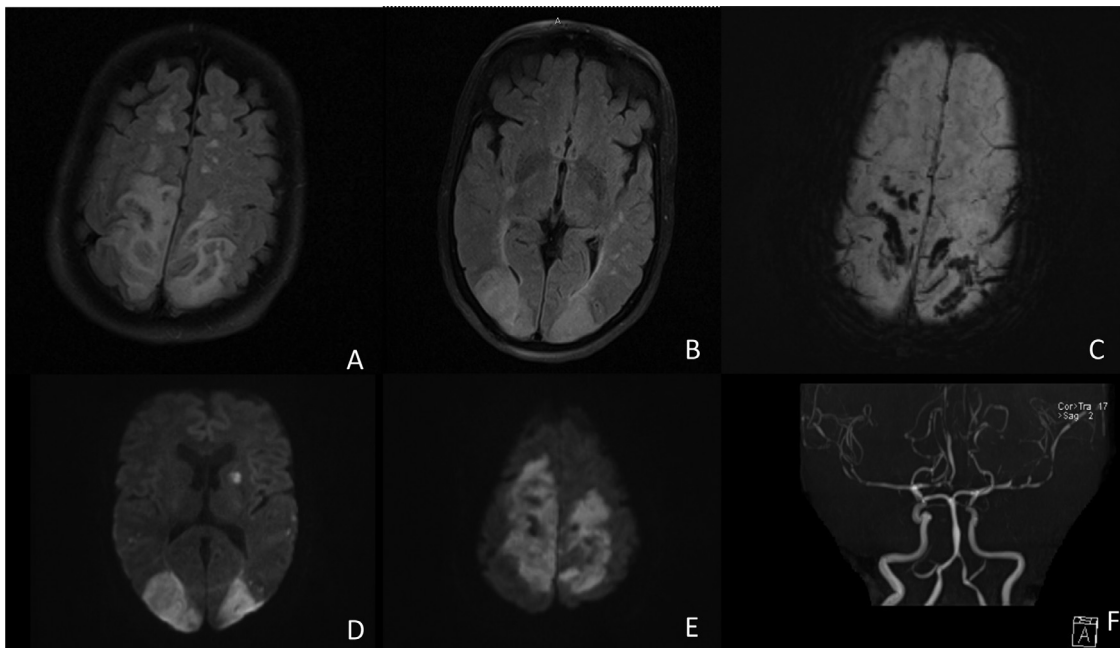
MRI brain (A) and (B) FLAIR sequences show grey and white matter hyperintensities in parieto occipital, fronto parietal region. (C) Susceptibility weighted image sequence shows haemorrhagic transformation of the lesions. (D) and (E) Diffusion weighted image sequences show diffusion restriction of bilateral occipital, fronto parietal and left capsuloganglionic region. (F) Intracranial MR angiogram shows widespread arterial vasoconstriction.
